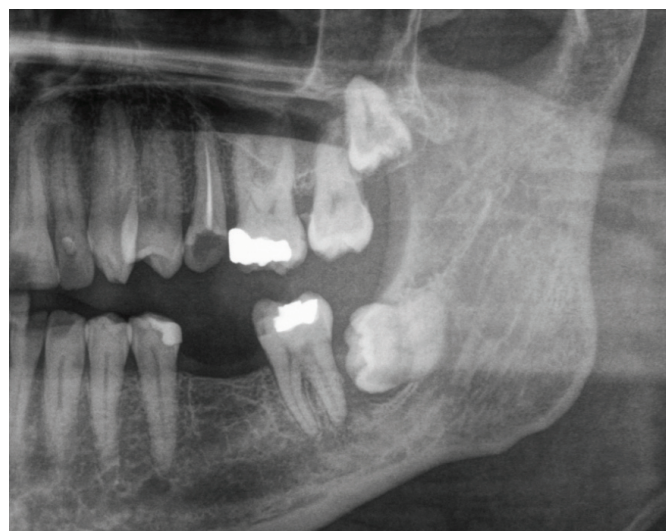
Radiograph showing severe alveolar bone loss along the distal aspect of LL7 as a direct result of LL8 impaction.
